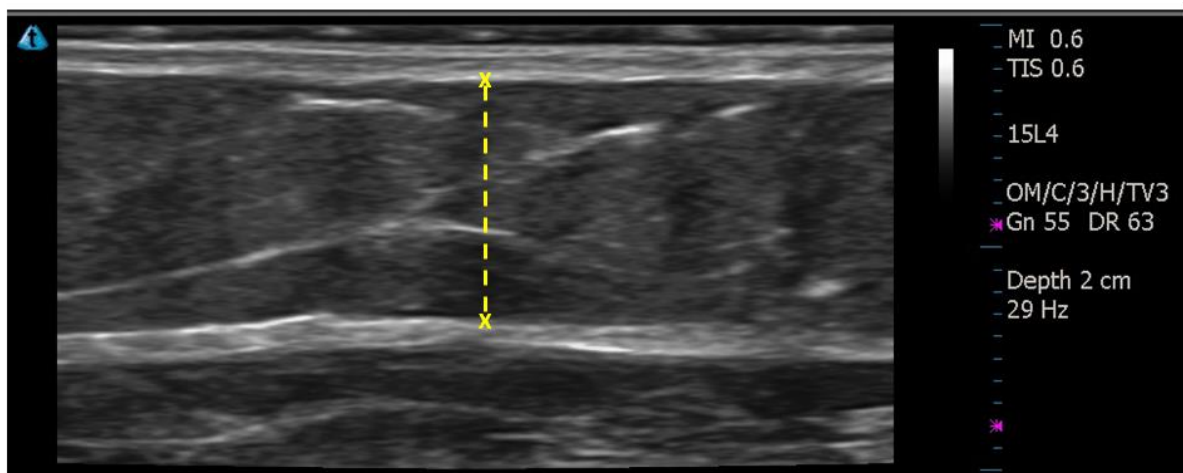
Subcutaneous adipose thickness via B-mode ultrasound.
